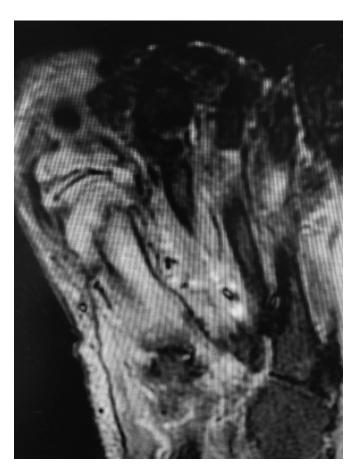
Magnetic resonance imaging study confirming osteomyelitis of the first metatarsal head.
